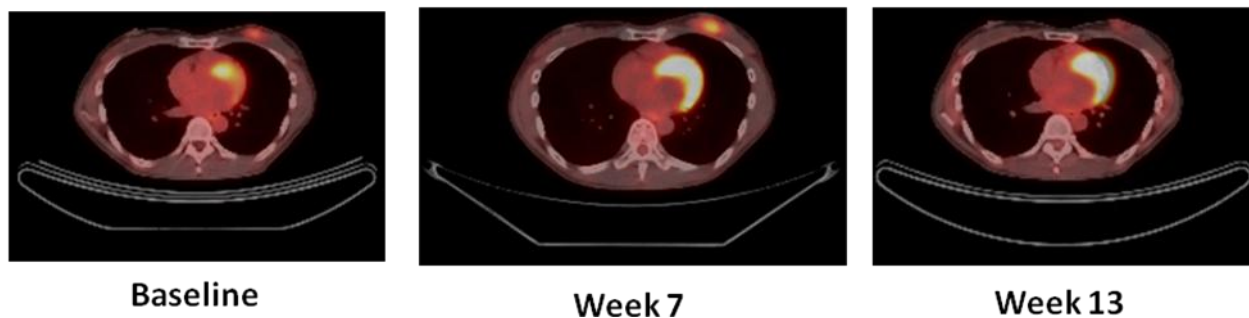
PET/CT Scan of a Patient with Extramedullary Relapse of AML in the left breast after 7 and 13 Weeks of Ipilimumab Dosing. At week 7, the size of the mass and its FDG avidity increased, possibly due to tumor flare, as with continued ipilimumab dosing by week 13 the mass had decreased significantly both in size and FDG avidity.
